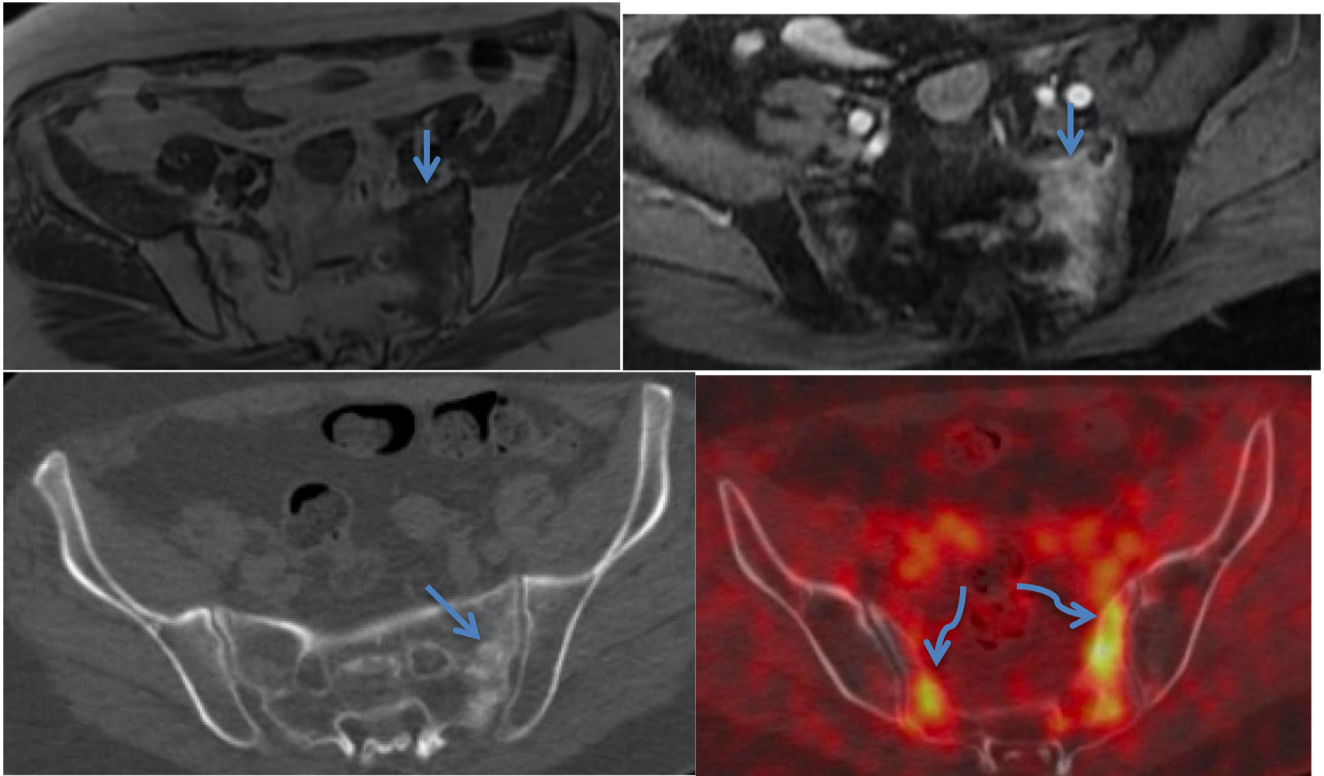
Case 3. Hypointense signal on T1 sequence and contrast material accumulation on left sacrum side (straight blue arrows). FDG-PET/CT showed active metabolic lesion in left sacrum side and smaller lesion in right sacrum side (curved blue arrows). Osteosclerotic areas are seen on CT images (straight blue arrow). (Color version of figure is available online.)
